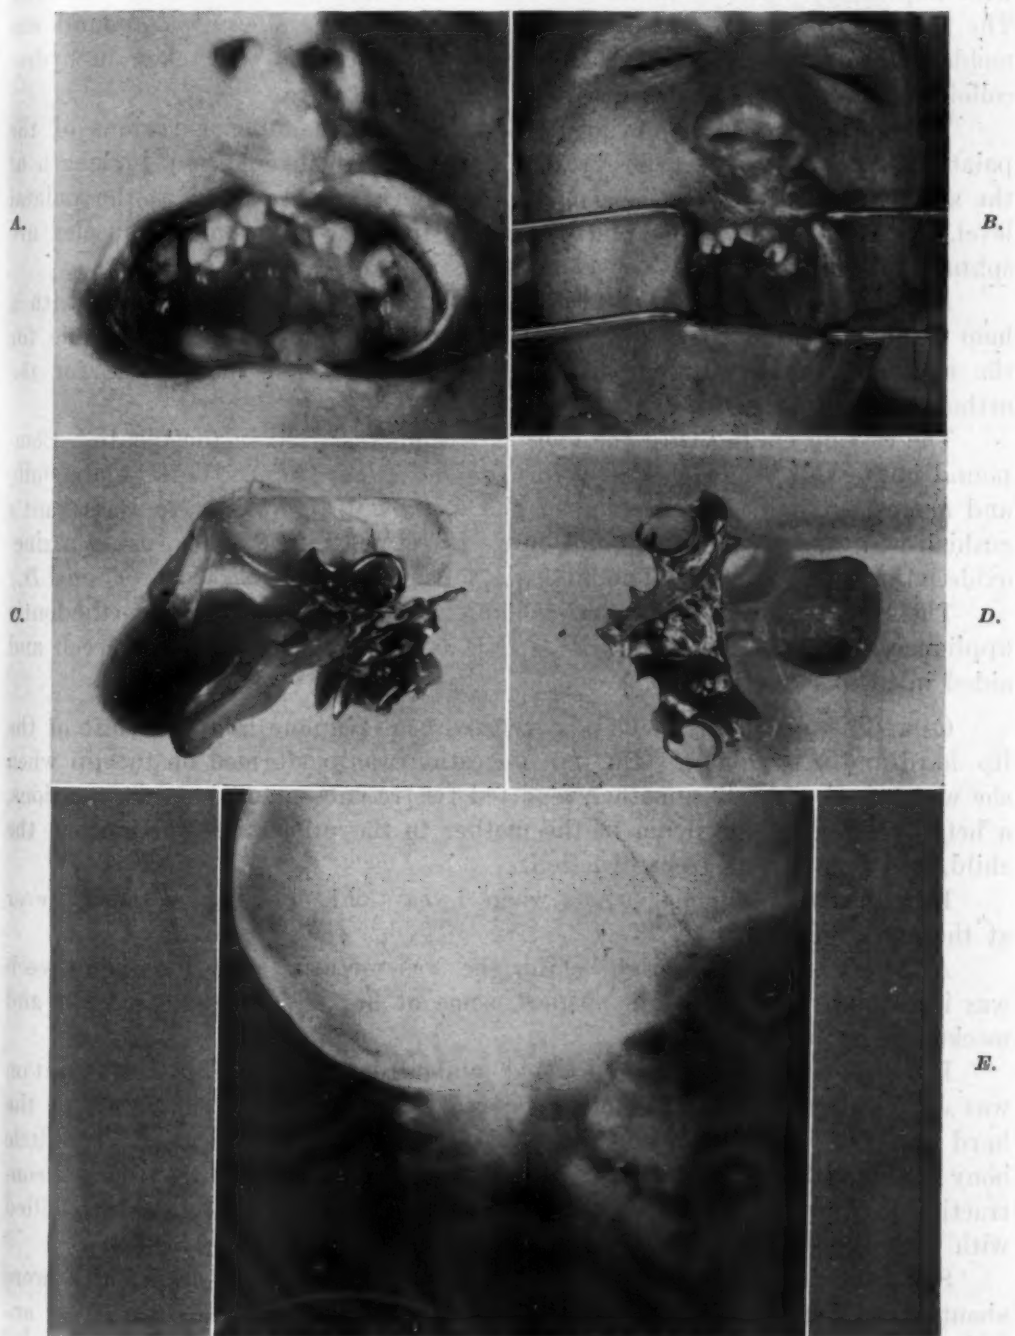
A, Oral view showing, grossly, inadequate soft palate terminating where soft palate normally begins. B, Oral view with obturator and velum supplementing deficient soft palate. C, Photograph of obturator and velum. Note 0.5 round tubes for orthodontic appliance. D, View of tissue side of appliance. E, Profile roentgenogram revealing lack of maxillary development aggravated by missing teeth.
